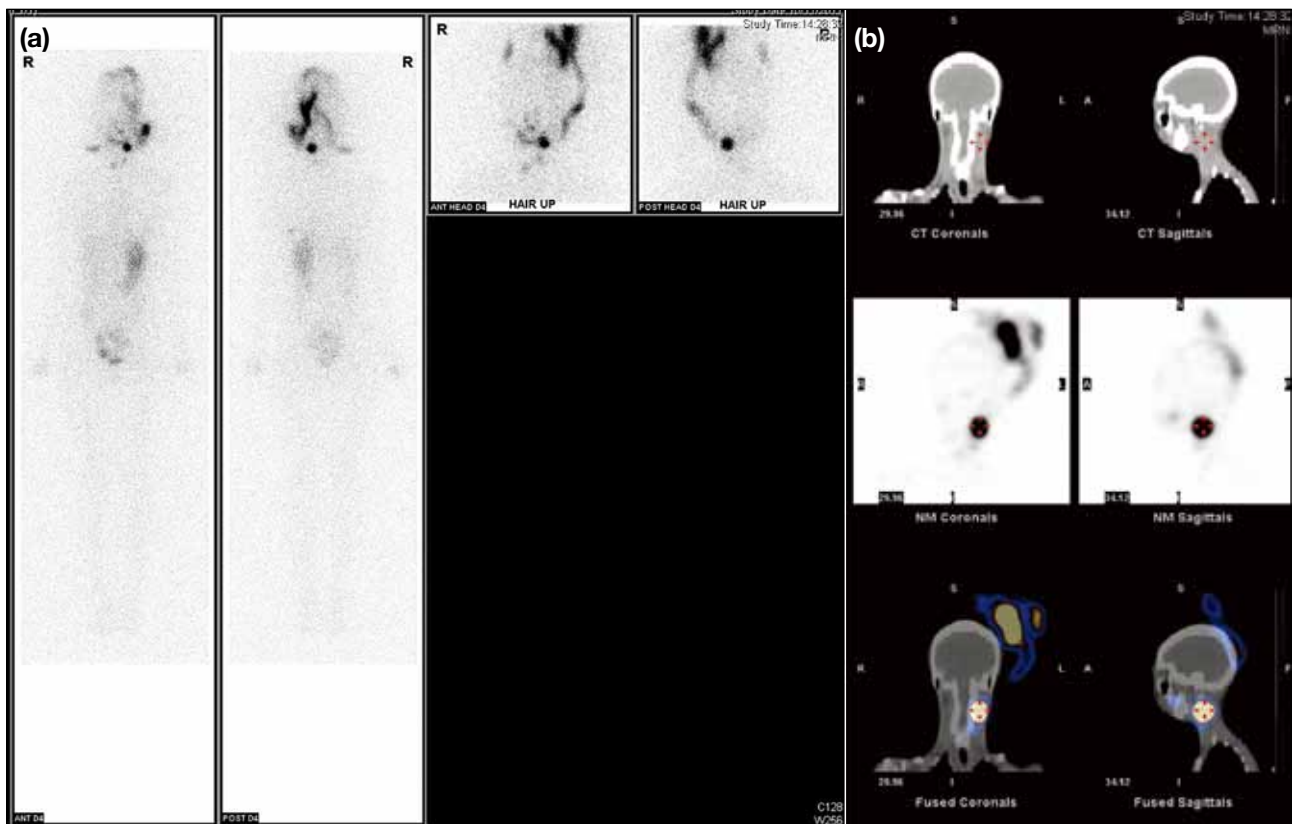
(a) Whole-body biplanar images show intense uptake over the left side of the neck suggestive of persistent residual local metastasis; there was also unusual linear uptake over both sides of the head and neck region that did not correspond to any anatomic structures, so additional localised views of the head with her hair up were performed. (b) SPECT/CT fusion images confirmed local cervical nodal metastasis in the left neck, and that the unusual linear uptake corresponded to artefactual hair contamination.
